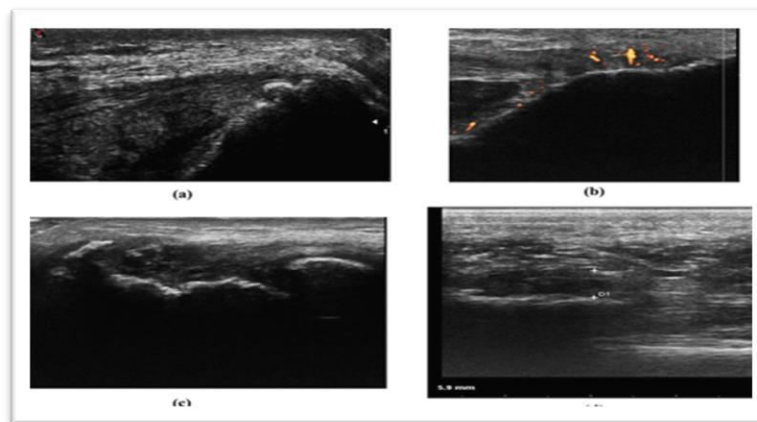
Characteristic sonographic findings of psoriatic enthesitis. (a).longitudinal suprapatellar ultrasound of the knee (grayscale)reveals a loss of fibrous structure at the superior pole of the patella, characterized by a hypoechoic appearance and signs of enthesitis at the quadriceps tendon insertion.(b).longitudinal infrapatellar ultrasound of the knee shows evidence of infrapatellar enthesitis, including thickening, hypoechoic appearance,loss of fibrous structure, and cortical irregularity observed on the power
